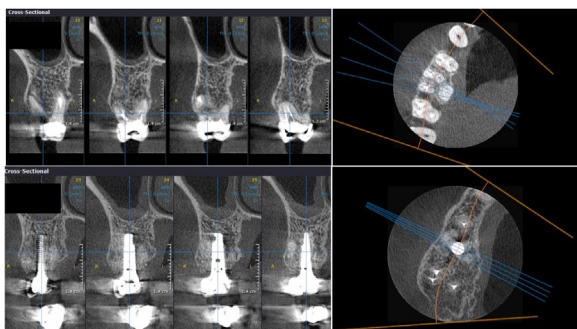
CBCT scan before surgery (up) and at 4 years follow up (down), showing implant position in the septum.
